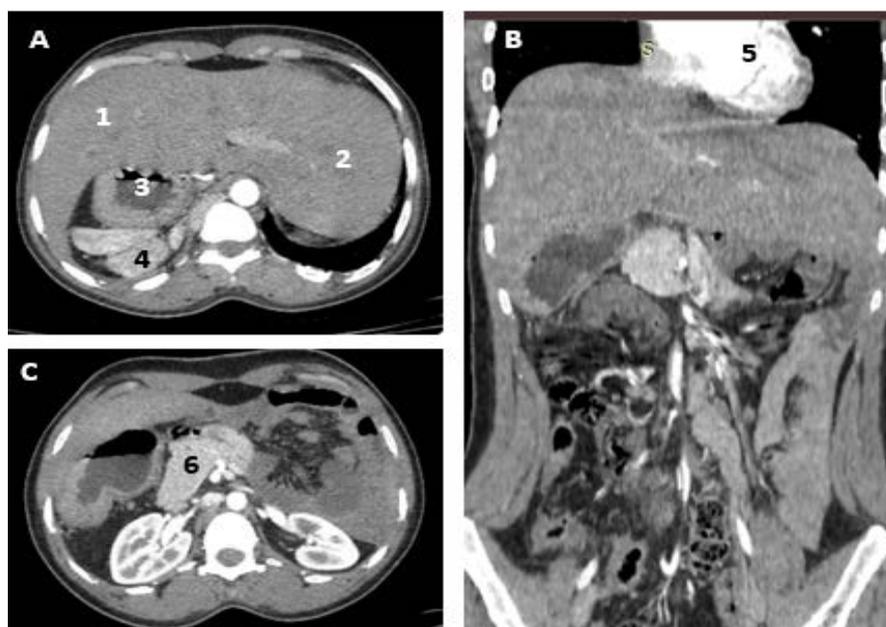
Abdominal-pelvic CT scan at late arterial time, axial sections (A) and (C) and coronal reformation (B). (A) Left liver (1) on the right; right liver (2) on the left; stomach (3) on the right; spleen (4) on the right. (B) Heart (5), located on the left. (C) Short pancreas (6) with head on the left and body on the right.
